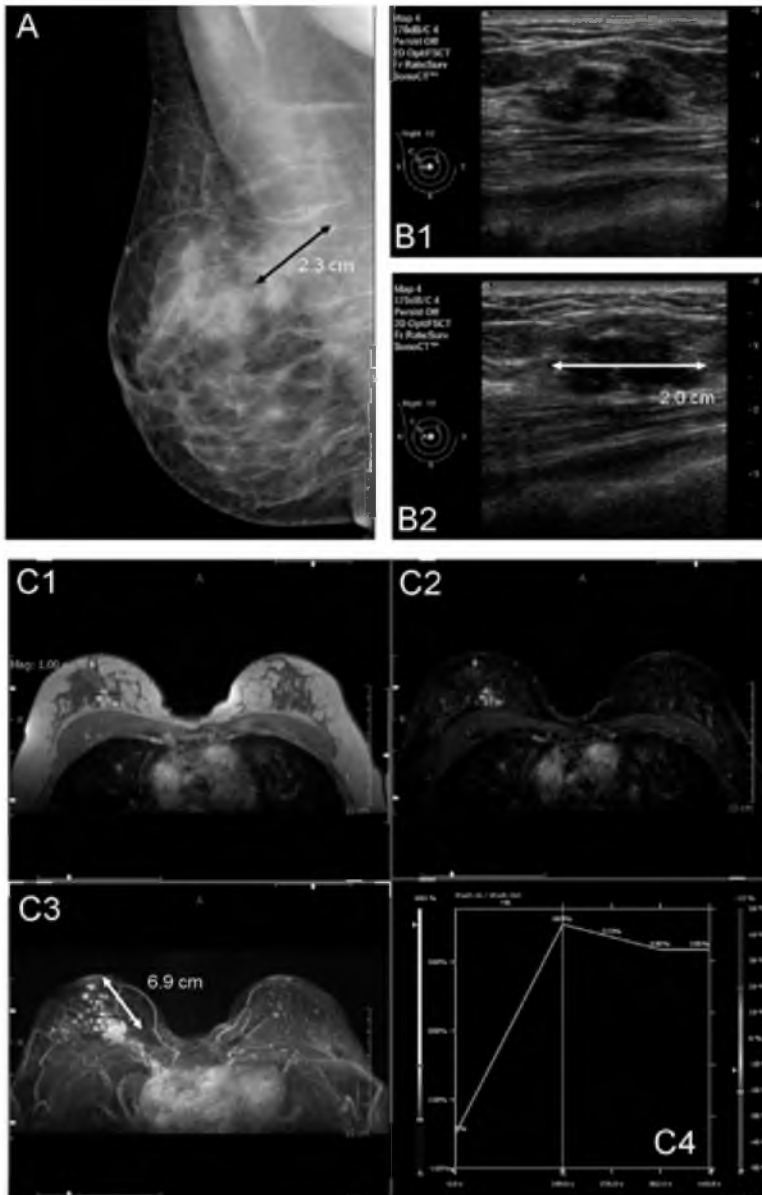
Images of a 37 year old women, known to be a BRCA2 mutation carrier. At mammography (A) an iso-intense spiculated mass was observed with a maximum diameter of 2.3 cm. At sonography (B) a hypoechoic mass with minimal posterior acoustic shadowing was observed. The maximum diameter of the tumor appeared to be 2.0 cm (B2). The MRI, shown in C (C1: native T1 post contrast acquisition, C2: subtraction image, C3: maximum intensity projection, C4: enhancement versus time curve corresponding with the crosshair in the other images) reveals a multifocal tumor over an area of 6.9 cm. Consequently mastectomy was performed. At pathology, a multicentric ILC was seen over an area of 7.3 cm.
